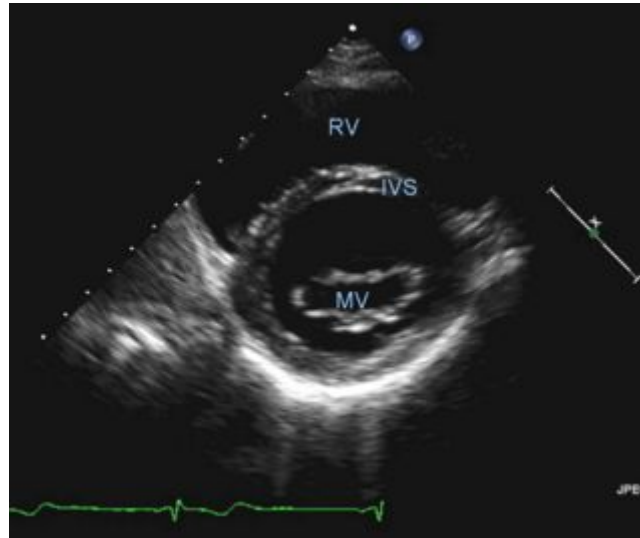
Normal parasternal short axis view (mitral valve level) (Andrew, Houghton2002)
